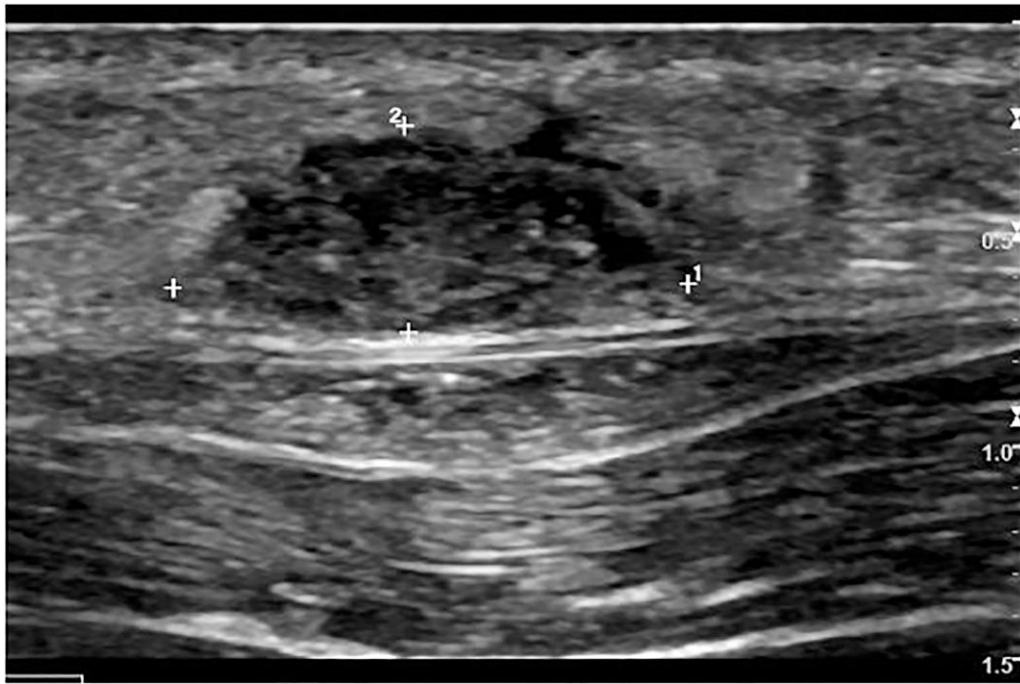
Ultrasound with 1.5 × 1.1 cm subcutaneous nodule. No foreign bodies were identified. Subcutaneous tissue measured 0.7 cm above muscular fascia.
